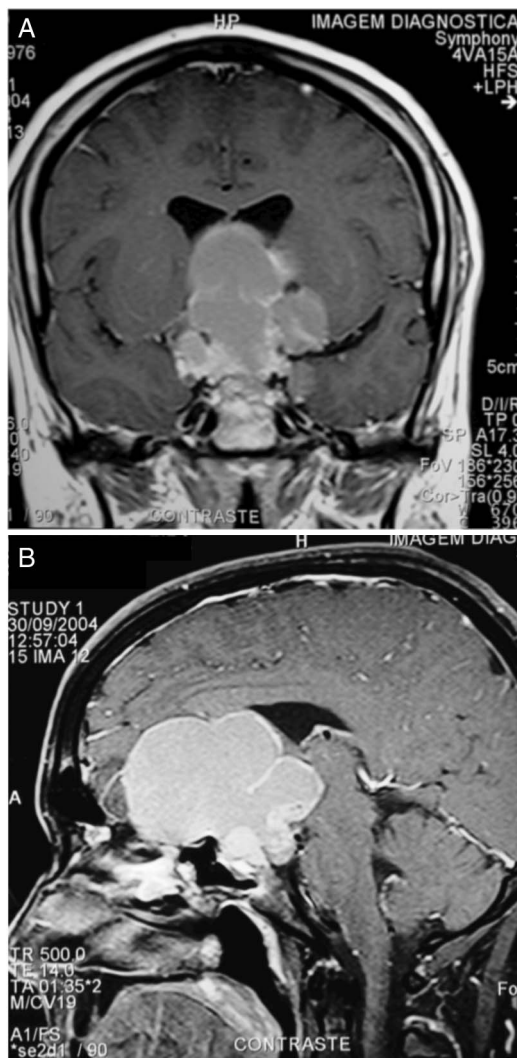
(A) MRI at diagnosis (coronal view). (B) MRI at diagnosis (sagittal view).
